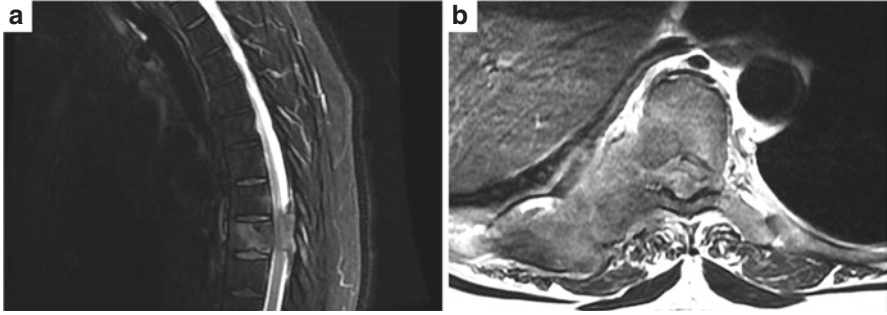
Preoperative MRI. (a) Sagittal T2 MRI with an osseous metastasis at T8. (b) Axial T2 MRI at T8 demonstrating complete loss of CSF surrounding the spinal cord with high-grade cord compression (ESCC3)
